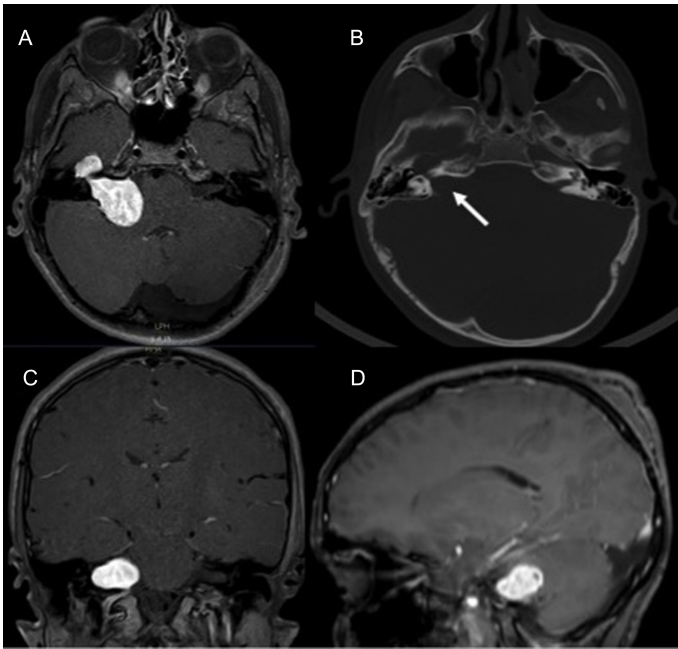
A: axial contrast-enhanced T1-weighted MRI shows enhancement of the right side mass. B: CT scan showing the tumor erosion of the right internal acoustic canal (white arrow). C and D: Coronal and sagittal MRI showing the mass effect of the tumor compression and displacing the brainstem. CT, computed tomography; MRI, magnetic resonance imaging.
